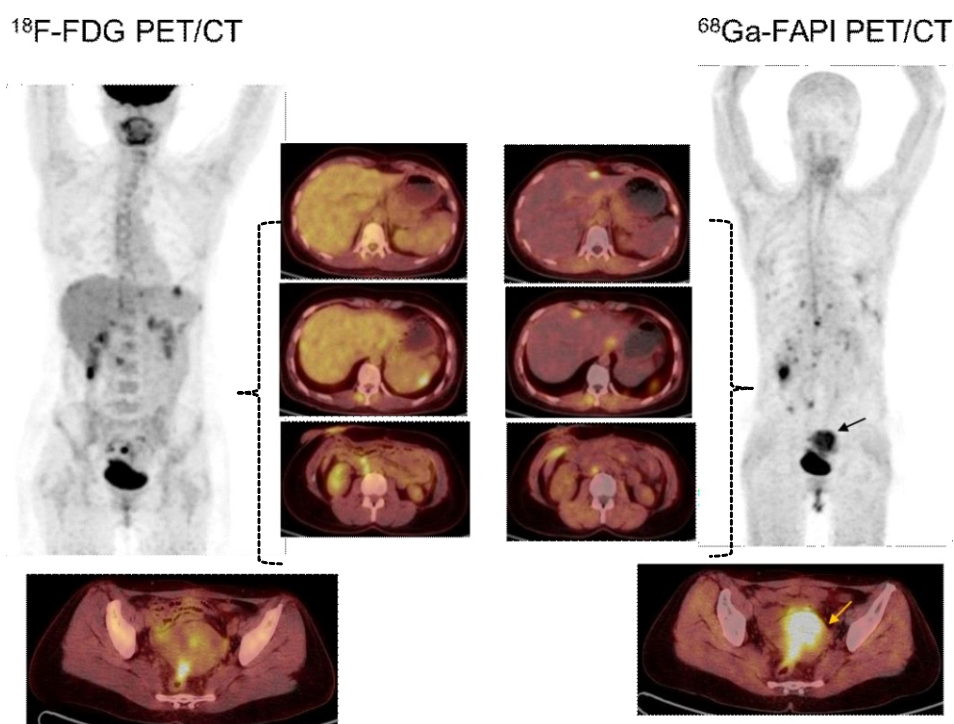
A 41-year-old woman with colon adenocarcinoma underwent hemicolectomy and chemotherapy before ^{18}F -FDG and FAPI scans. Patient results: 1) Hypermetabolic RLQ mass lesion is compatible with peritoneal seeding. Fibroblast activation protein inhibitor uptake is consistent with peritoneal seeding, and liver nodules are peritoneal. 2) Two hypermetabolic right renal artery lymph nodes, which, given the patient's history, suggest metastatic involvement. Left basal lung infiltration with ^{18}F -FDG and FAPI uptake suggests inflammation. 3) Three hypermetabolic small lesions in the right liver lobe (segment 8) suggest metastatic involvement with ^{18}F -FDG non-avidity. Moreover, higher uptake was seen in the uterus in the right lower image in the MIP of the ^{68}Ga -FAPI-46 PET/CT scan.
